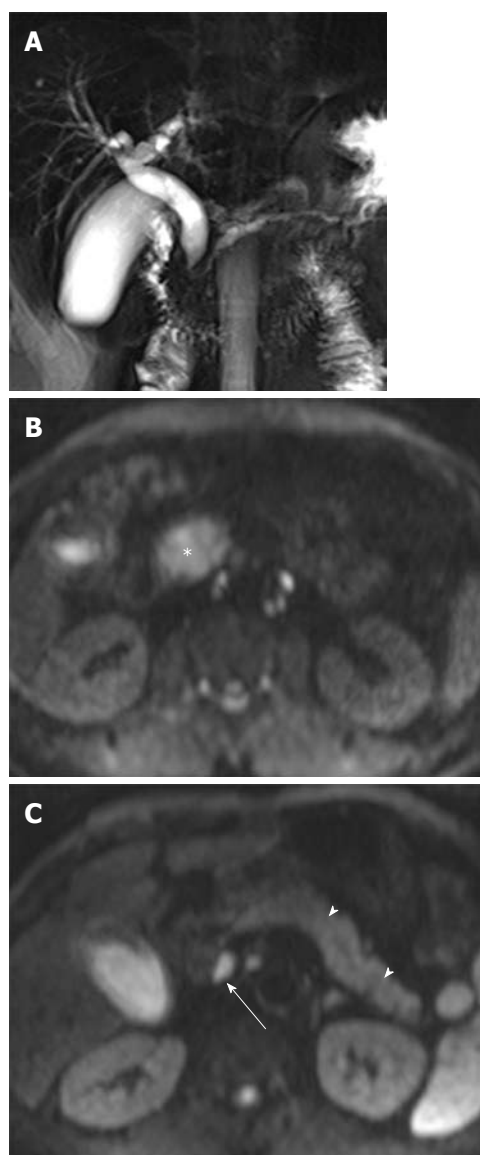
Focal pancreatitis in a 52-year-old man. A: Coronal image from thick-slab single-shot MRCP shows a double duct sign with tapered narrowing of pancreatic duct in the head of the pancreas; B: On DWI at $b = 800 \text{ s/mm}^2$ focal pancreatitis (asterisk) shows hyperintensity; C: DWI at $b = 800 \text{ s/mm}^2$ superior to (B) shows high signal intensity of the remaining pancreas due to obstructive pancreatitis. The remaining pancreas is slightly hypointense (arrowheads) relative to pancreatic adenocarcinoma. The ADC value of focal pancreatitis ($1.48 \pm 0.16 \text{ mm}^2/\text{s}$) is similar to that of the remaining pancreas ($1.54 \pm 0.28 \text{ mm}^2/\text{s}$). Note a hyperintense reactive lymph node (arrow). DWI: Diffusion-weighted magnetic resonance imaging; MRCP: Magnetic resonance cholangiopancreatography; ADC: Apparent diffusion coefficient.
